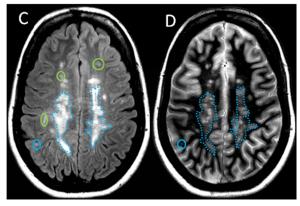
3T FLAIR (A,C) versus 7T-WHAT (B,D): WHAT better separates individual lesions from large confluent lesions on FLAIR (dashed outline, arrows). Two example lesions marked blue are seen with both sequences, but more conspicuous on FLAIR. Lesions marked green are only seen on FLAIR, Lesions seen only on WHAT are marked red.
